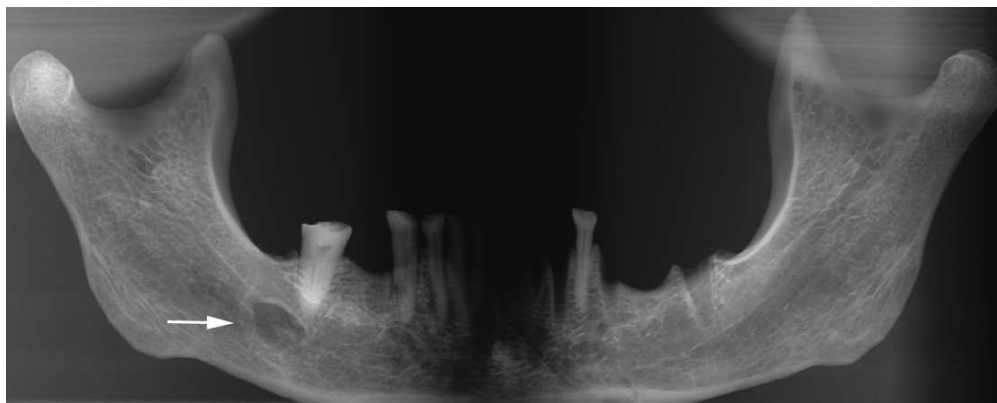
Orthopantomograph of mandible 138 from Rua dos Barcos, revealing a unilateral well-defined unilocular radiolucent oval lesion on the right side below the inferior alveolar canal.
